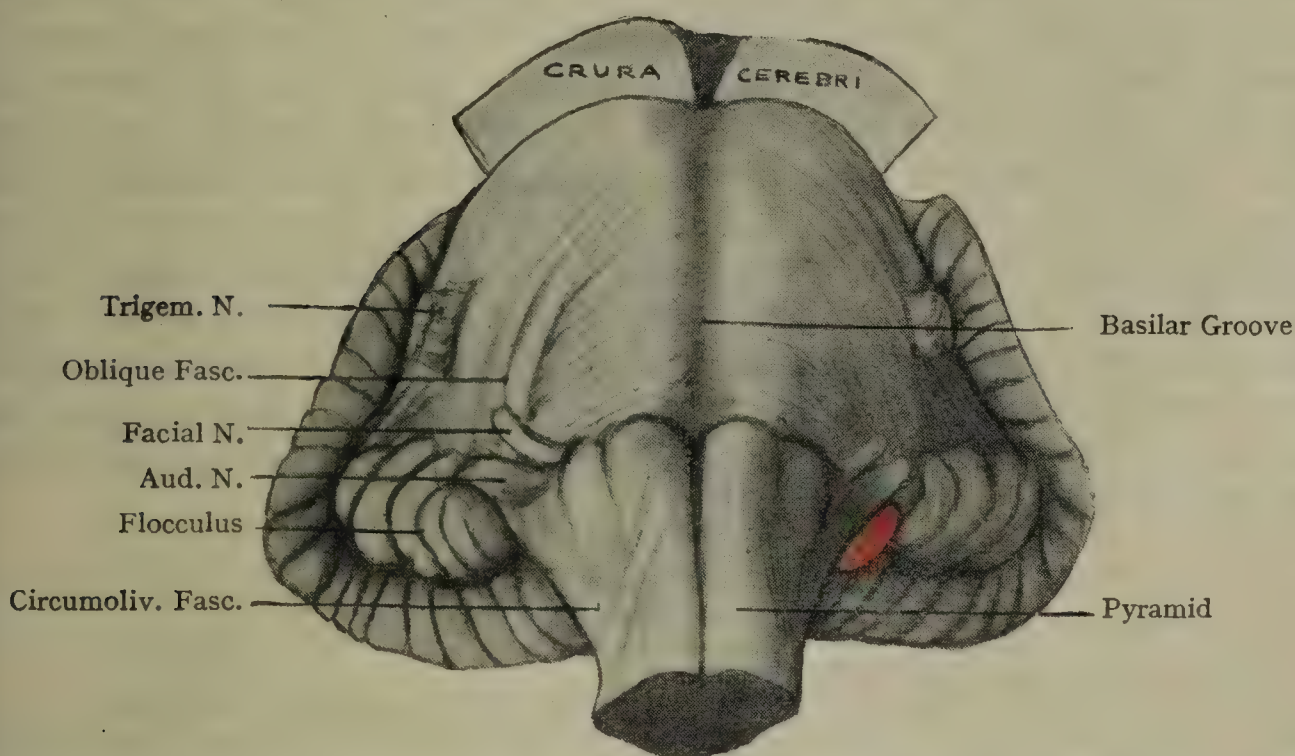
FRONT ASPECT OF PONS AND MEDULLA, SHOWING OBLIQUE FIBRES OF PONS AND ARCUATE FIBRES ON MEDULLA.
